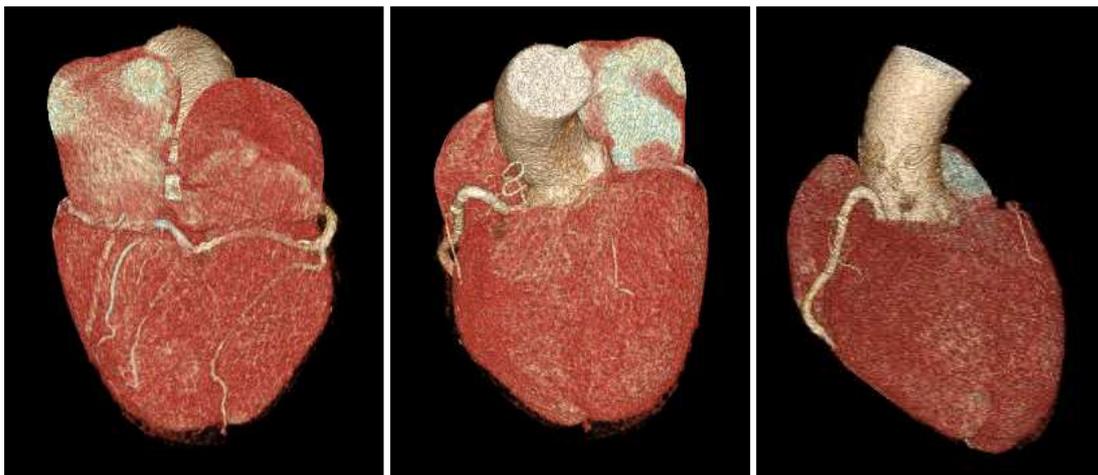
Coronary computed tomography angiography with 3D reconstructions depicting a single coronary artery with its ostium in the right sinus of Valsalva
